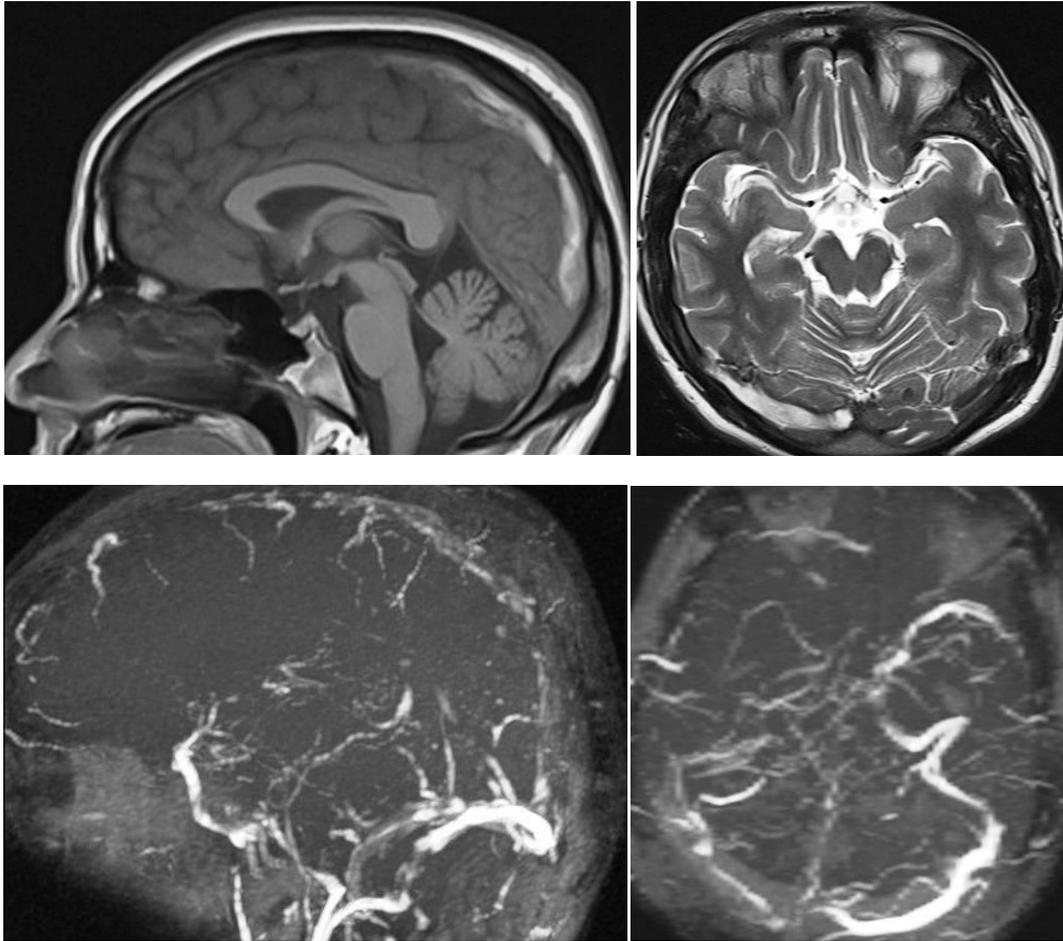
20 year old primi, post LSCS with motor weakness and seizure. CT and MRI showed sigmoid, transverse, superior sinus thrombosis with bilateral thalamic and right frontoparietal haemorrhagic infarcts.
